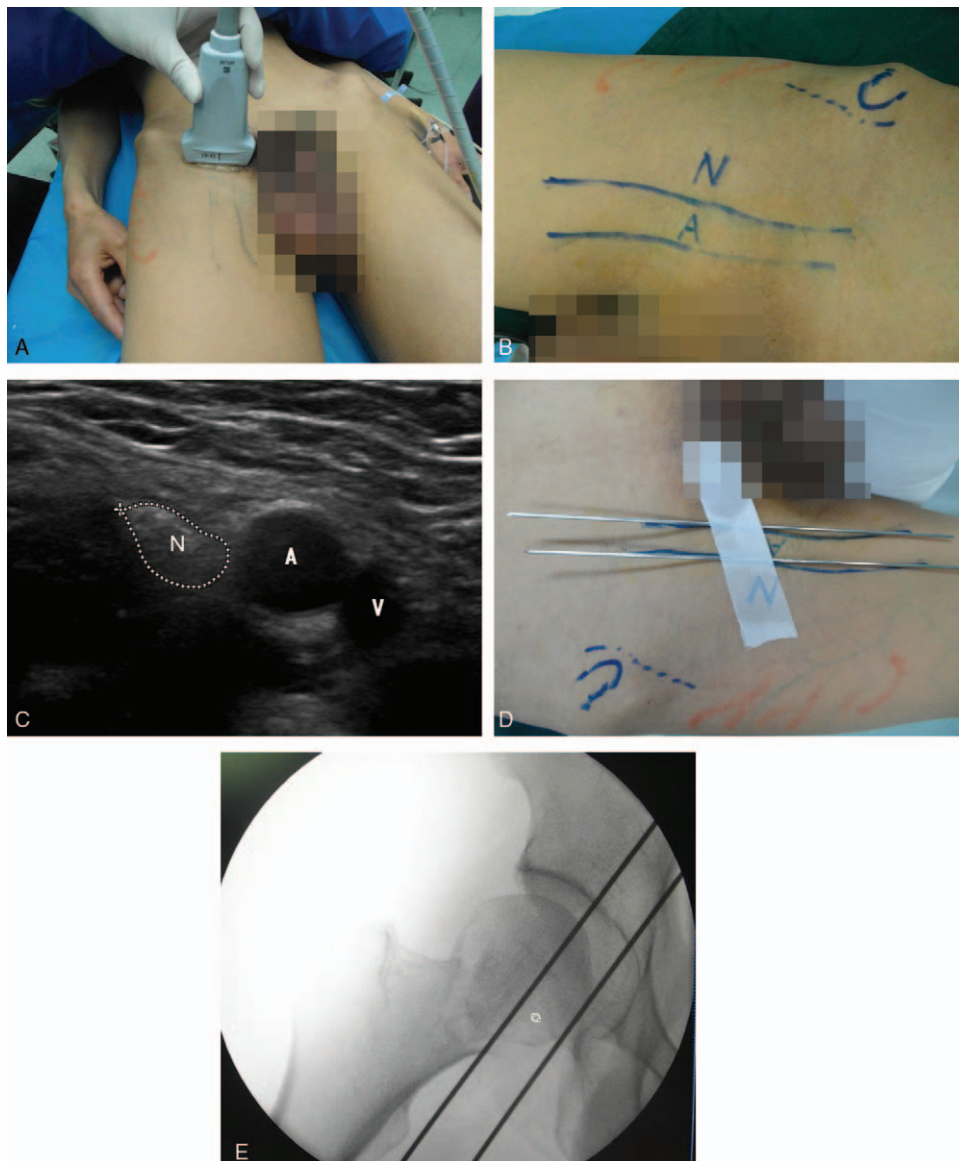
(A) Ultrasound localization; (B) Surface labeling; (C) Ultrasound shows femoral artery and femoral vein; (A: arteria femoralis, V: femoral vein, N: nervus femoralis) (D) Fix the Kirschner wire in the marked position; (E) The vertical projection position of the femoral vein under the perspective of the C-arm.
